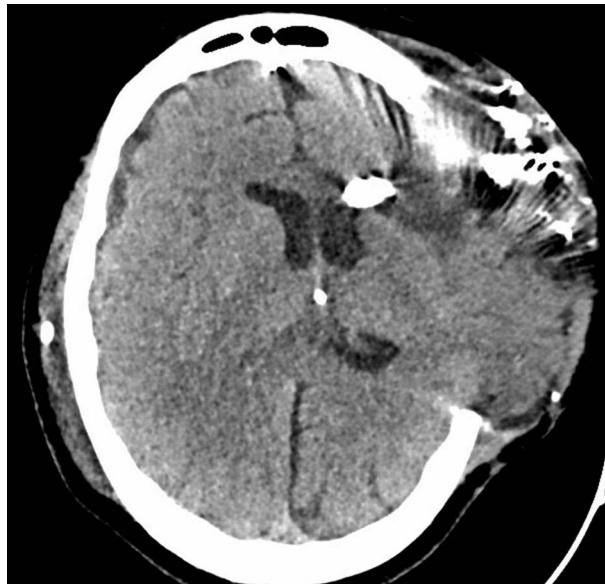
Axial view of the head CT showing VP shunt placement, right to left cerebral midline shift, and external brain herniation.
